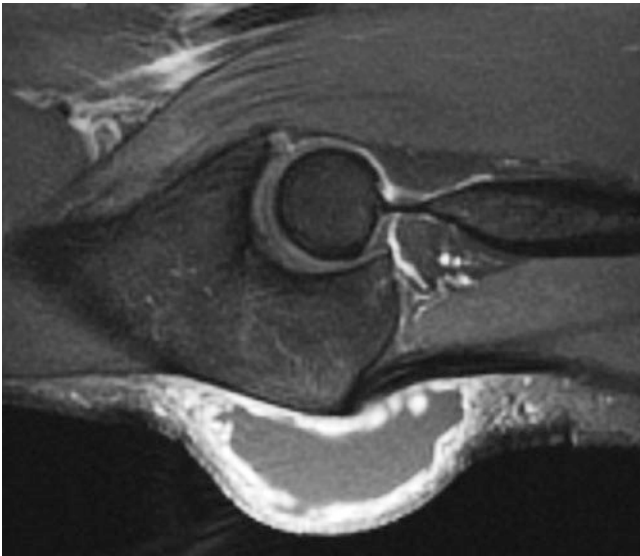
Olecranon bursitis. Sagittal fat-saturated T1-weighted image demonstrates marked synovial enhancement in a distended olecranon bursa. Used by permission of Springer Nature
